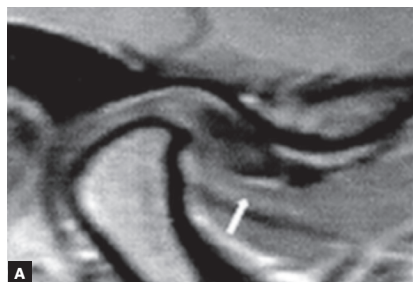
A) Detail of MRI sagittal slice of the right TMJ with mouth closed, evincing displacement of the TMJ articular disc. B) MRI sagittal slice of the right TMJ at maximal mouth opening, in which ADDWR is evident.
